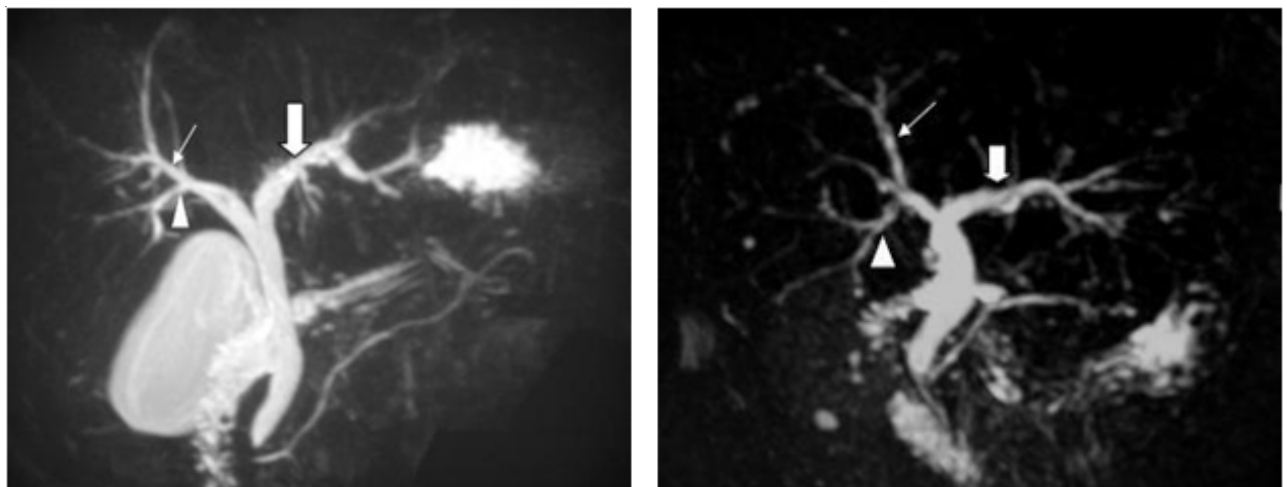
Conventional pattern of hepatic ductal anatomy in two patients A: a 43-year-old man with hepatitis B and HIV infection. MRCP shows normal confluence of right posterior duct (arrowhead) and right anterior duct (small arrow) to form right hepatic duct. Right hepatic duct fused left hepatic duct (large arrow) to form common hepatic duct. B: a 72-year-old woman with mild intrahepatic bile duct dilatation in check-up ultrasound. The right hepatic duct is formed by fusion of the right anterior duct (small arrow) and right posterior duct (arrowhead). The common hepatic duct is formed by fusion of the right hepatic duct and the left hepatic duct (large arrow).
